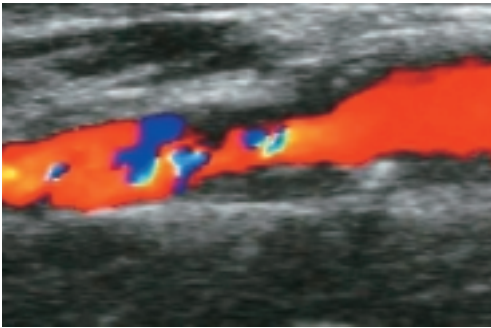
Colour Doppler ultrasound shows a 90-per-cent stenosis of the left internal carotid artery.
